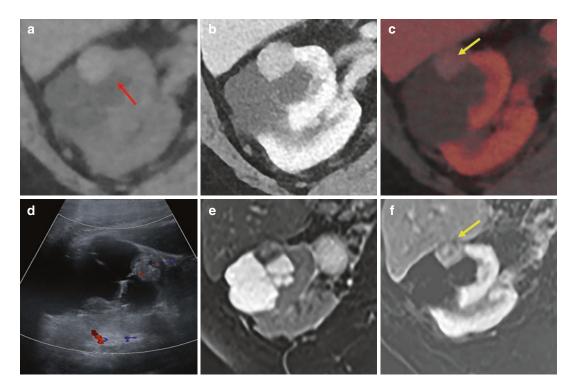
Virtual non-contrast (a), Contrast enhanced (b), and iodine map (c) of a dual energy CT of Bosniak IV cyst with solid nodule. Focus of hyperattenuation on virtual non-contrast (a, red arrow) indicates hemorrhagic material, which also shows subtle enhancement centrally more apparent on iodine map (c, yellow arrow).
